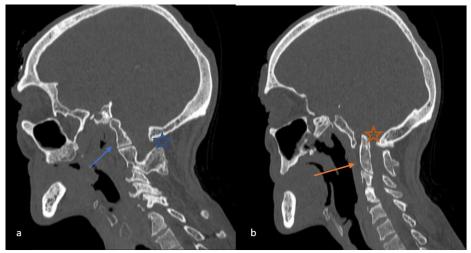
Sagittal CT bone window images (a, b) showing a posterior arch defect of the atlas (C1) (a; blue asterisk), complete fusion of the anterior arch of C1 with the occipital bone (a; blue arrow) indicating anterior atlanto-occipital assimilation, complete fusion of the vertebral bodies of C2 and C3 (b orrange arrow) consistent with Klippel-Feil syndrome type II and basilar invagination (b; orrange asterisk).
